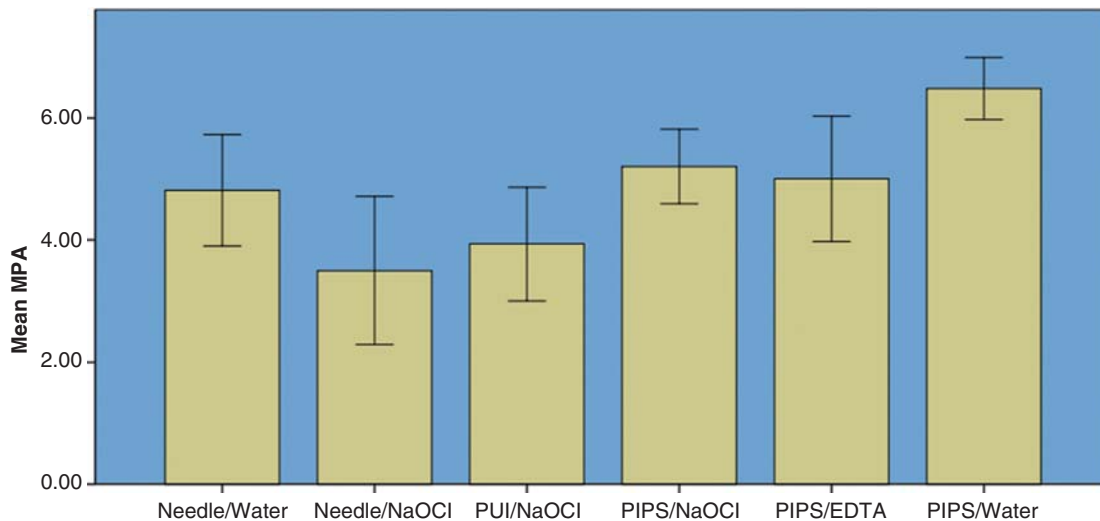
Mean bond strength of self-adhesive resin cement to root dentin after needle irrigation, ultrasonic irrigation, and PIPS.
